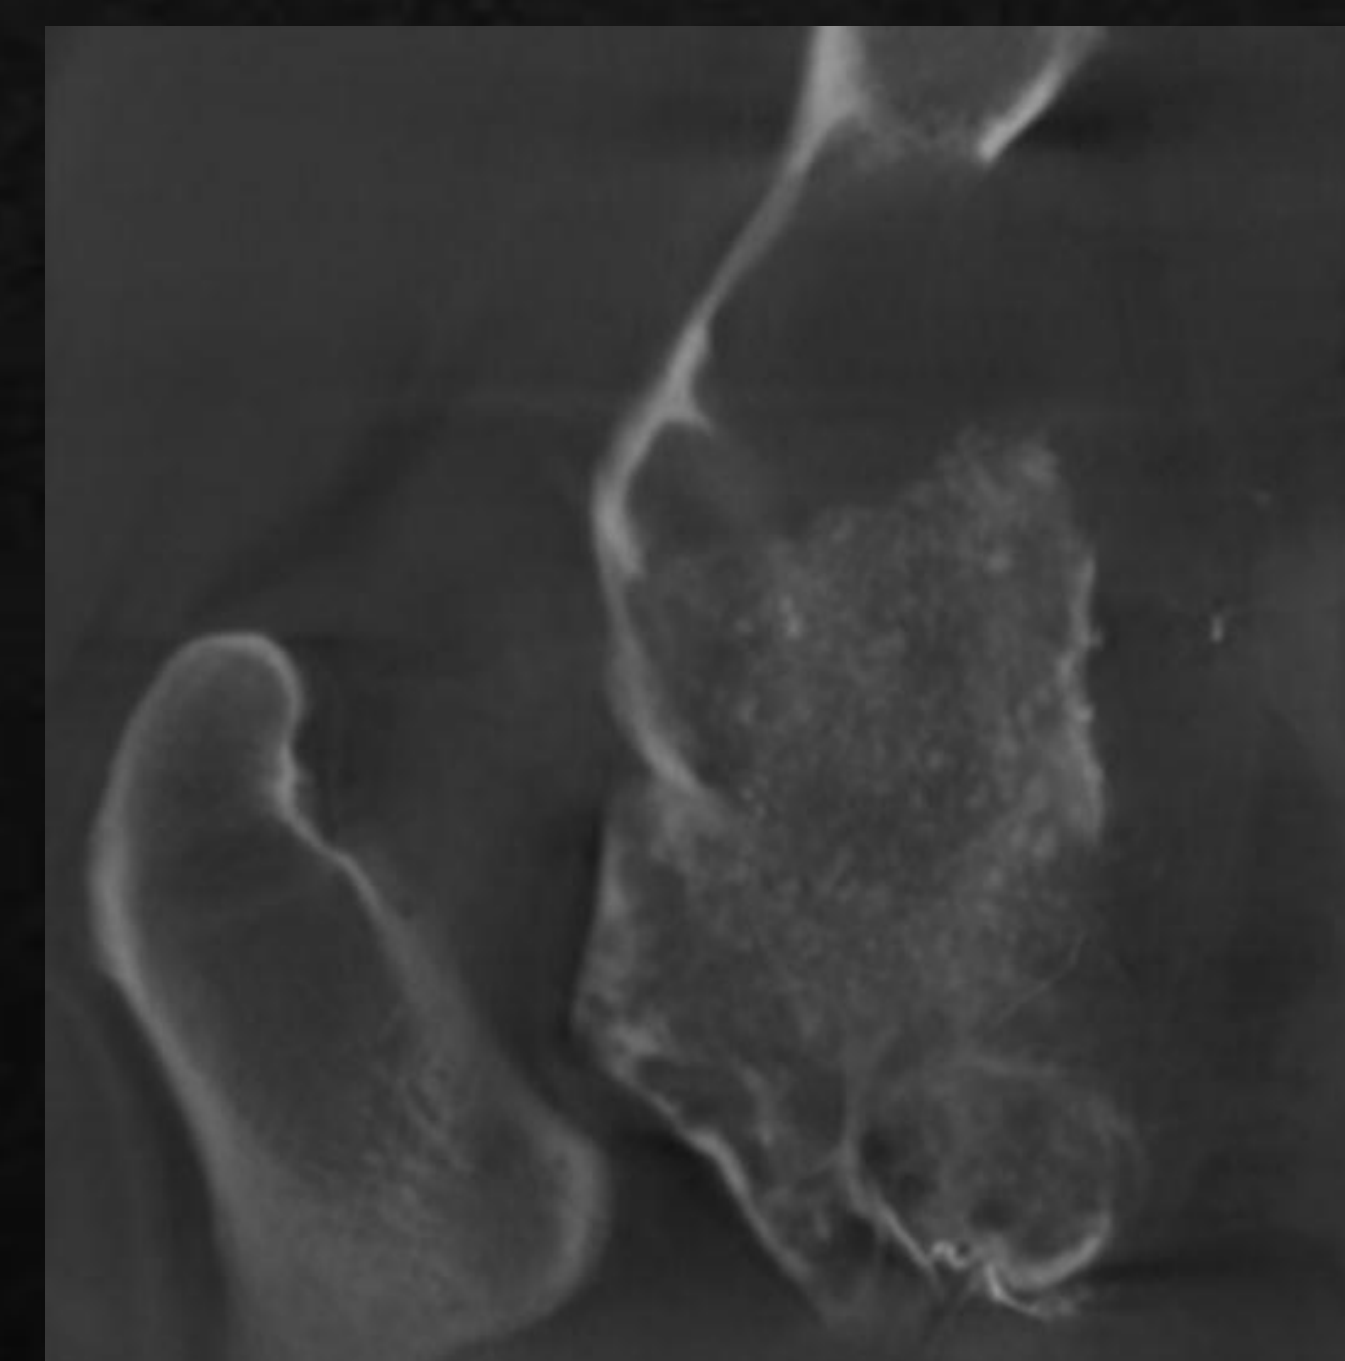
Post-STs sclerotherapy cone beam CT
